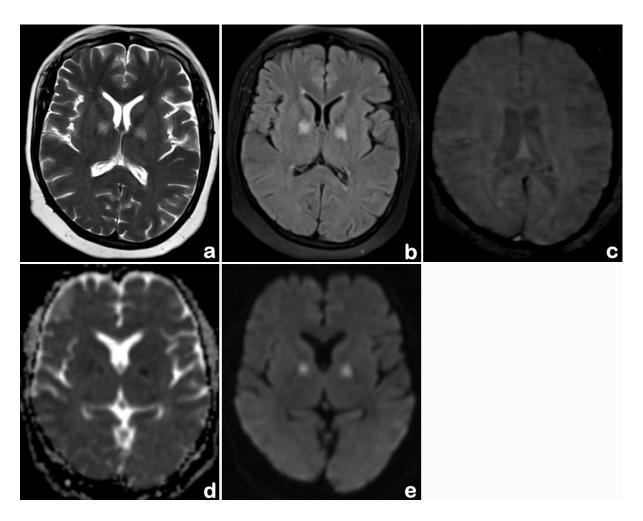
Axial T2 weighted (a) and FLAIR image (b) show symmetric hyperintensity involving the Globus pallidi with striking diffusion restriction on the diffusion weighted trace image (e) and corresponding ADC map (d). Note the subtle hyperintensity in the corpus callosum splenium on the T2 weighted (a) and FLAIR image (b) with microbleeds on SWI (c). Involvement of the Globus pallidi is suggestive of a hypoxic injury in a background of HACE.
